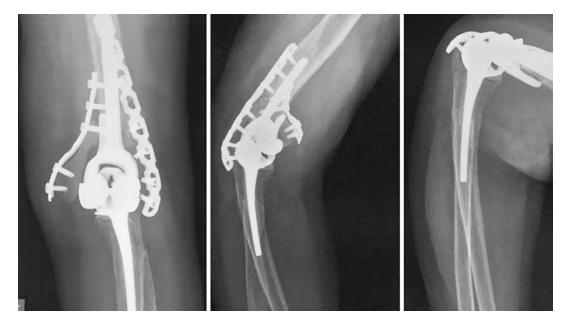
Postoperative X-ray at 4 months' follow-up. Coonrad-Morrey prosthesis with accurate reconstruction of medial and lateral columns
